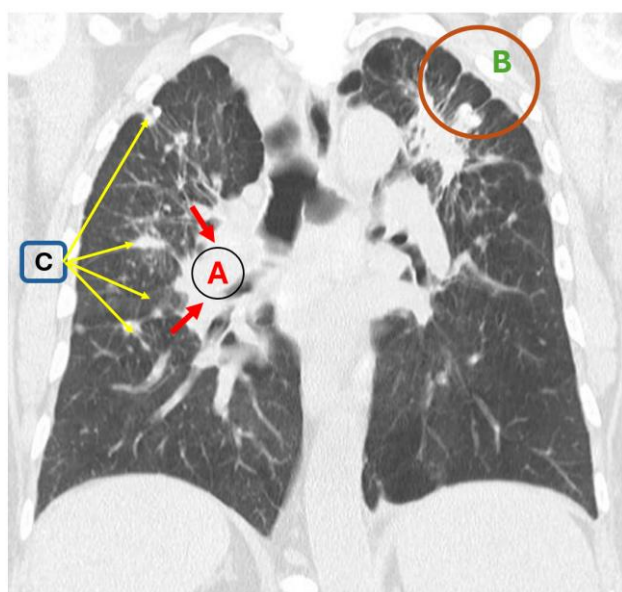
High-Resolution Computed Tomography of Silicosis: Progressive Masive Fibrosis⁶
